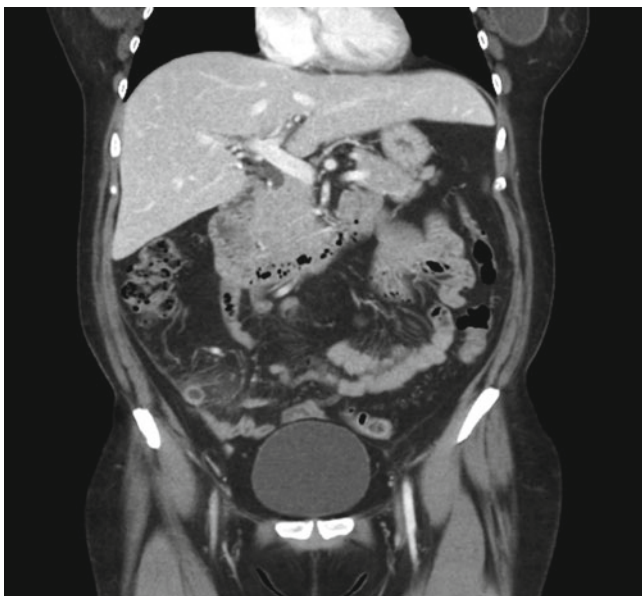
Coronal CT of the abdomen showing the inflamed appendix in the right lower quadrant
